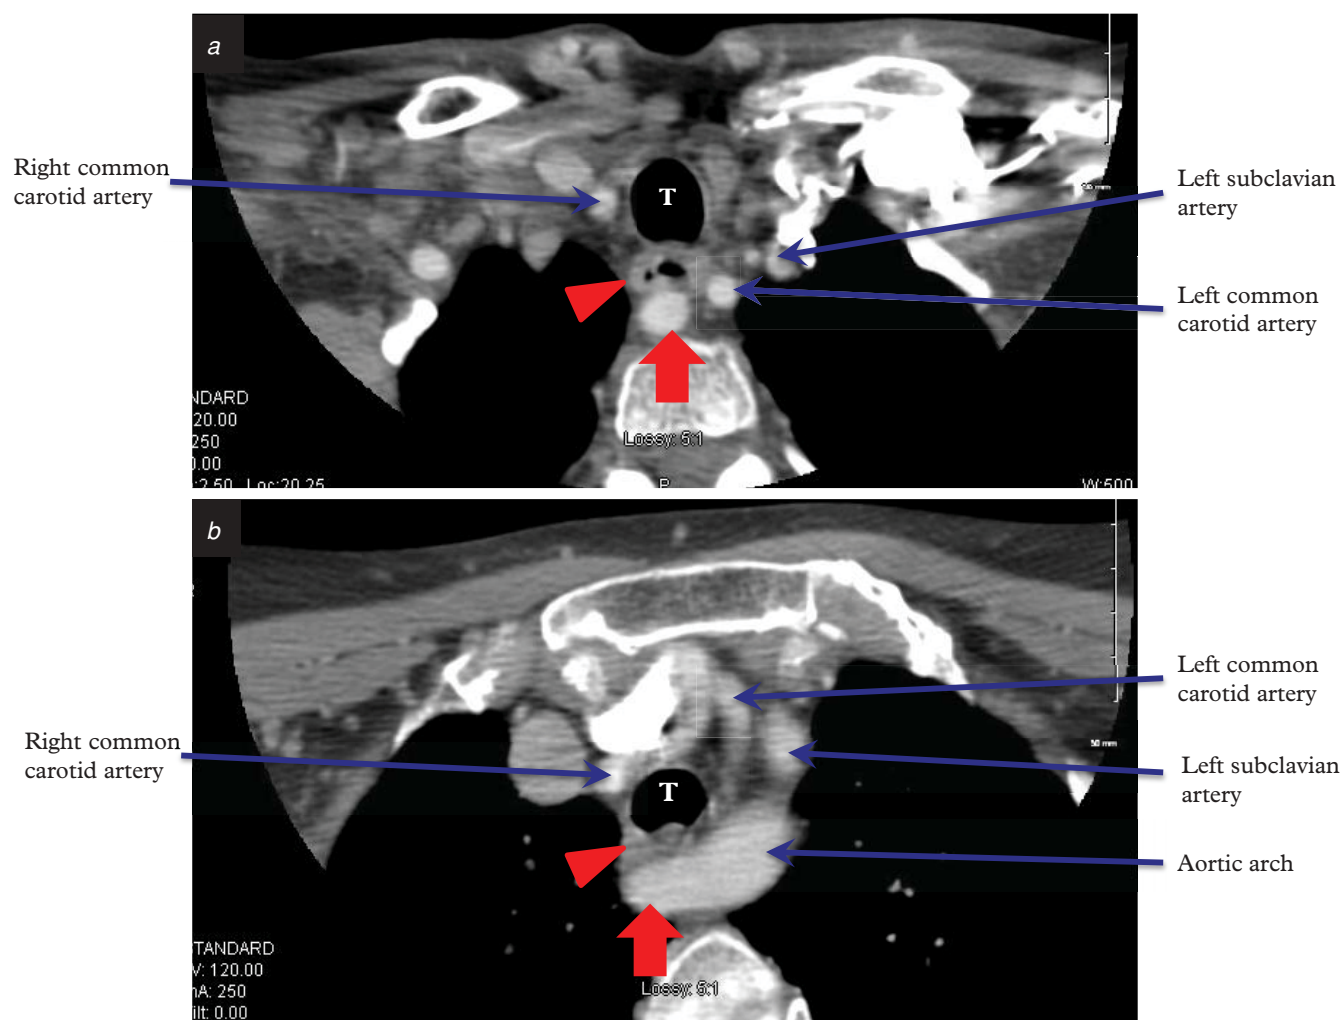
Dysphagia lusoria. Contrast-enhanced CT scan of the upper chest at the level of the clavicular heads (a) and near the carina (b) demonstrating the retroesophageal course of the right subclavian artery (arrow) causing compression of the esophagus (arrowhead) against the trachea (T) and right carotid artery. One can appreciate the idea of a “vascular ring” in such cases causing esophageal compression.
